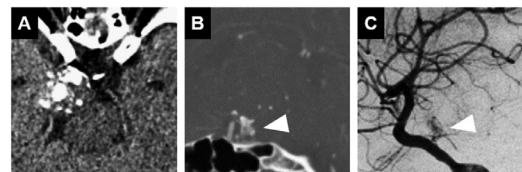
Preoperative radiological studies. Computed tomography shows a calcified lesion (A) and blistering of the right posterior clinoid process (B; arrowhead). Digital subtraction angiography shows a vascular supply from the right meningohypophyseal trunk (C; arrowhead)
